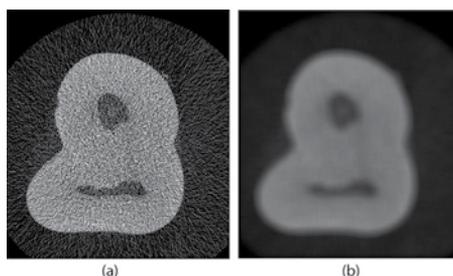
Application of Gauss filter on a CBCT image. (a) Original image with noise; (b) image after the application of the Gauss filter.
